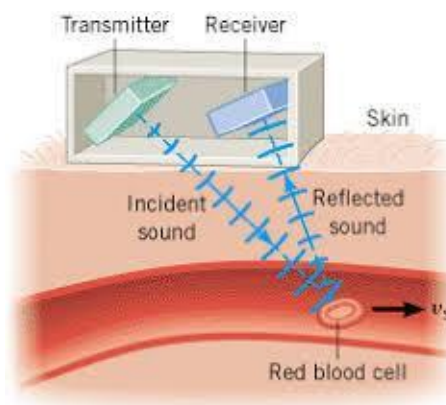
Ultrasonic blood flow meter.
